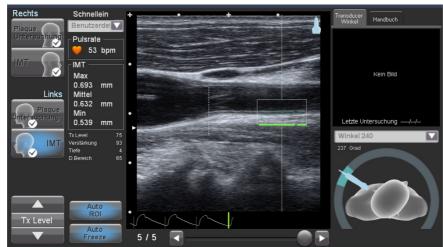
Ultrasound of the cIMT at A. carotis communis (longitudinal)
